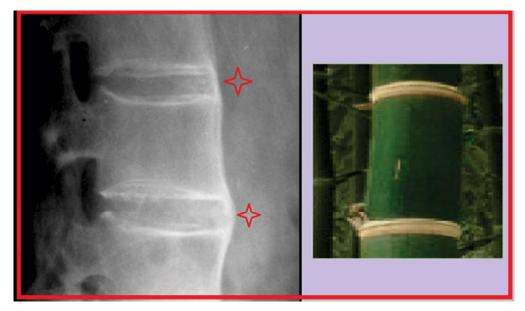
A radiograph showing ankylosing spondylitis with well-formed syndesmophytes, as denoted by the red stars. These osteophytes are said to resemble the culms, or rings, of bamboo, shown in the image to the right. Thus, the radiographic appearance of ankylosing spondylitis is termed "bamboo spine." (Case courtesy of Frank Gaillard, Radiopaedia.org, rID: 7163)
